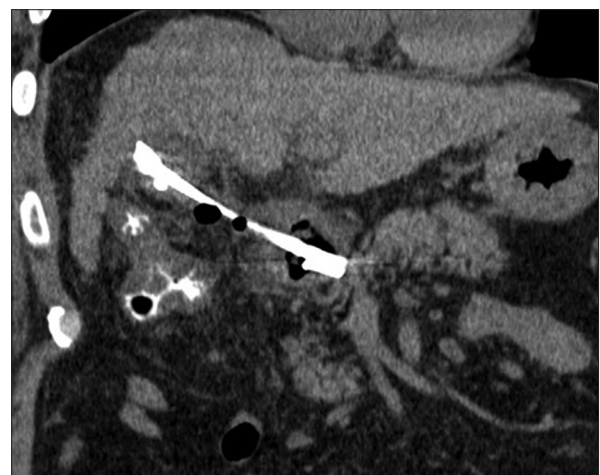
The CT performed after the EUS-GBD procedure showed proper placement of EUS-GBD plastic stent with no evidence of bile leakage or local complication
